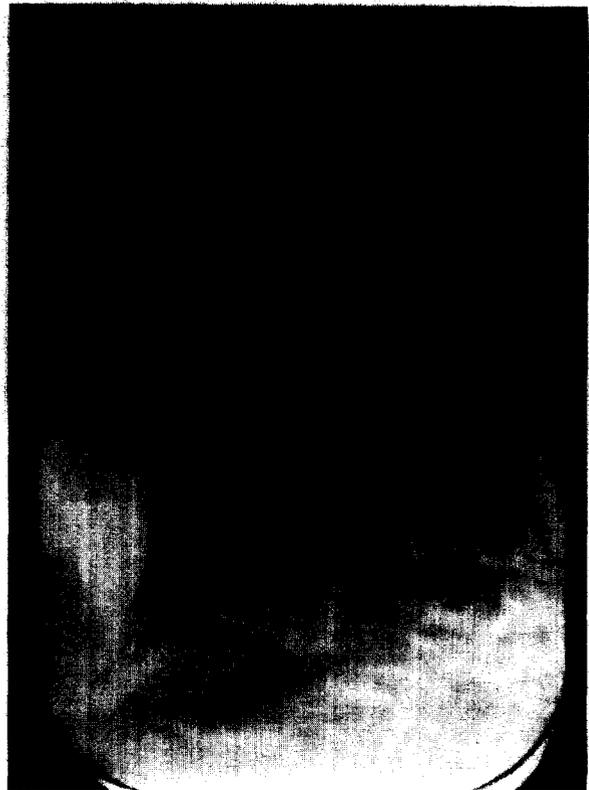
Intraoral radiograph of lower incisor teeth.
